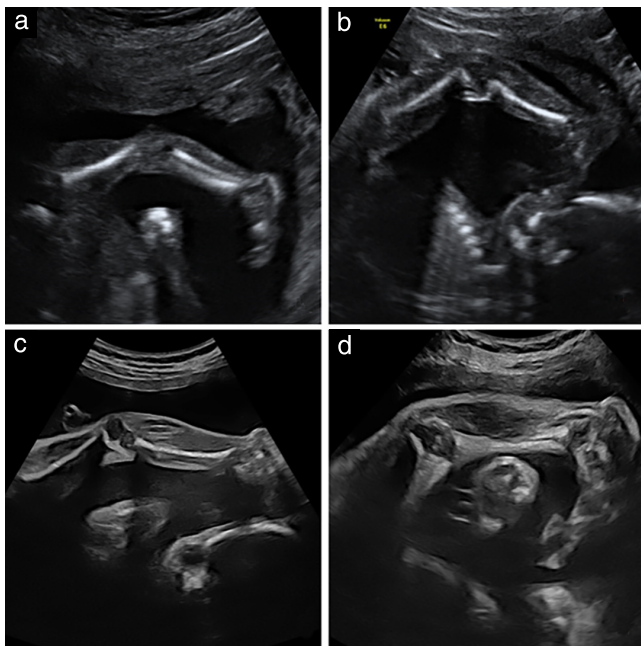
Longitudinal prenatal ultrasound in a case with isolated congenital knee dislocation (CKD). At 12 weeks, both legs and knees were normal (not shown). (a) At 16 weeks, diagnosis of CKD with 30–45° hyperextension was made. (b) At 20 weeks, diagnosis was confirmed with 45° hyperextension. (c,d) At 26 weeks (c), 32 weeks (d) and 36 weeks (not shown), persistence of anomaly with stable degree of hyperextension was observed. Extensive anatomy survey was carried out during each prenatal assessment, demonstrating normal anatomy and normal range of movements in all joints, with exception of affected knee, which was immobile at all assessments.
